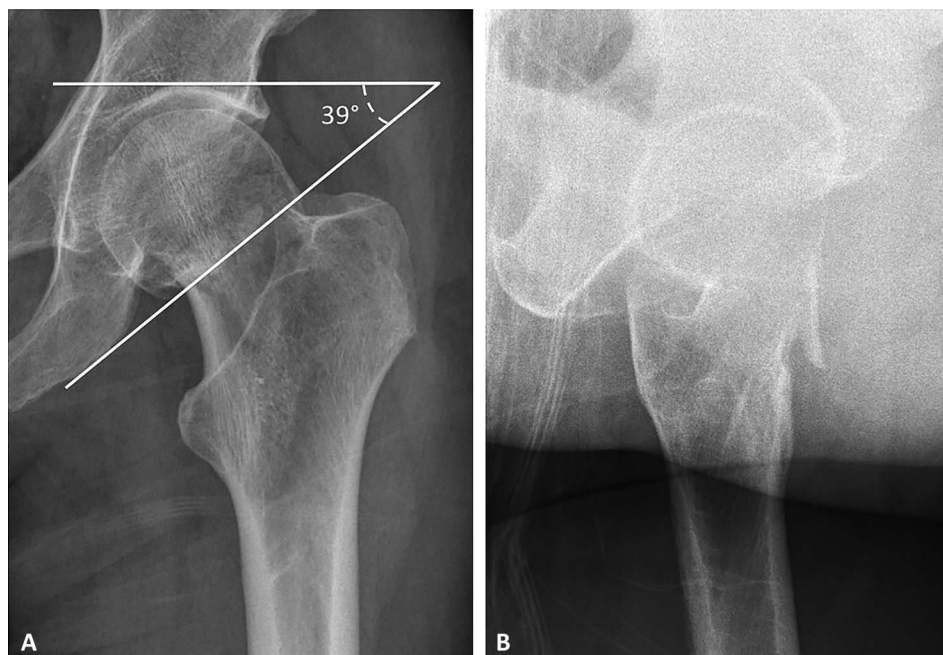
Anteroposterior (A) and lateral (B) radiographs of a Pauwels II femoral neck fracture in a 52-year-old man after low-energy trauma (a fall from <3 feet).
